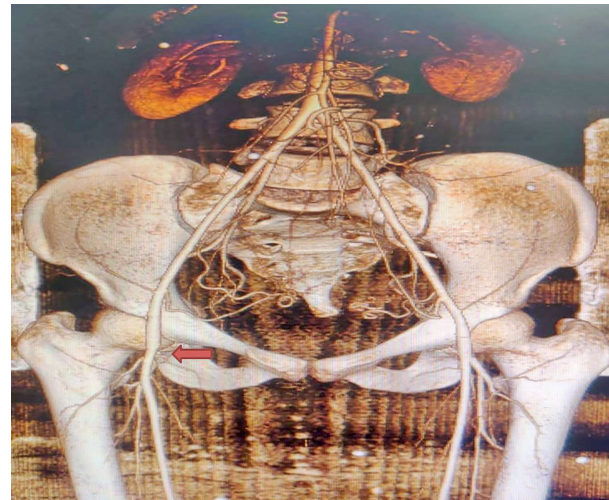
3-D reconstruction image of CT aortogram showing mild narrowing of right femoral artery at the previous puncture site
